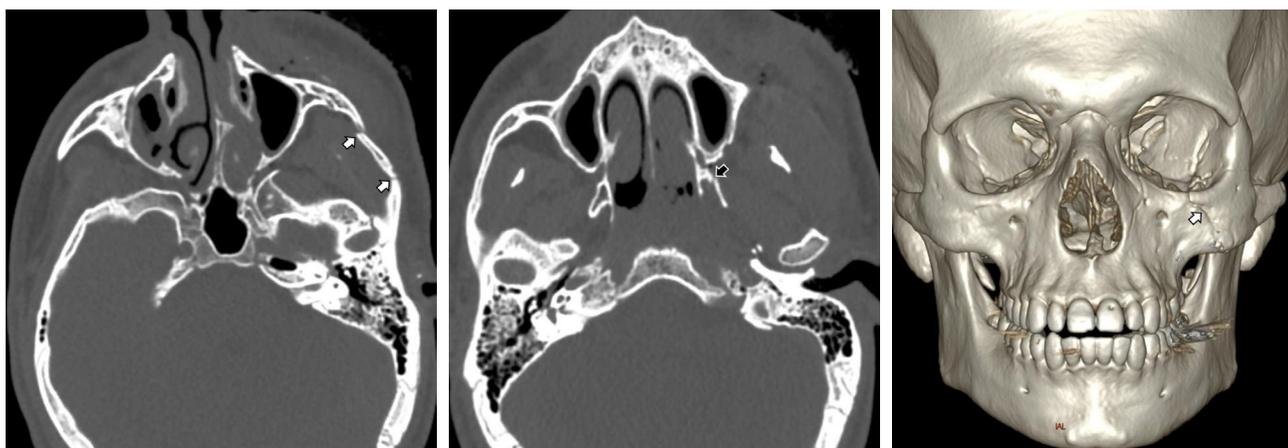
A 28-year-old man with zygomaticomaxillary complex fracture. Axial (a) CT image shows the left zygomaticomaxillary complex fracture (white arrows). The fracture extends into the ipsilateral pterygoid plates (b, black arrow). Coronal reformatted CT image (c) reveals the maxillary components of this complex fracture (white arrow).
